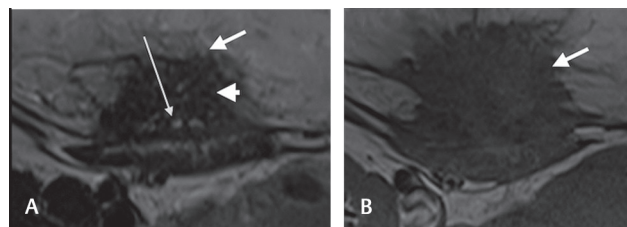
(A, B) T2W (A) and T1W (B) axial images showing a spiculated mass (*short arrow*) with internal hyperintense foci suggestive of ectopic endometrial tissue (*long arrow*) with surrounding hypointensity suggestive of fibrosis and smooth muscle hypertrophy (*arrowhead*). T1W, T1-weighted; T2W, T2-weighted.
